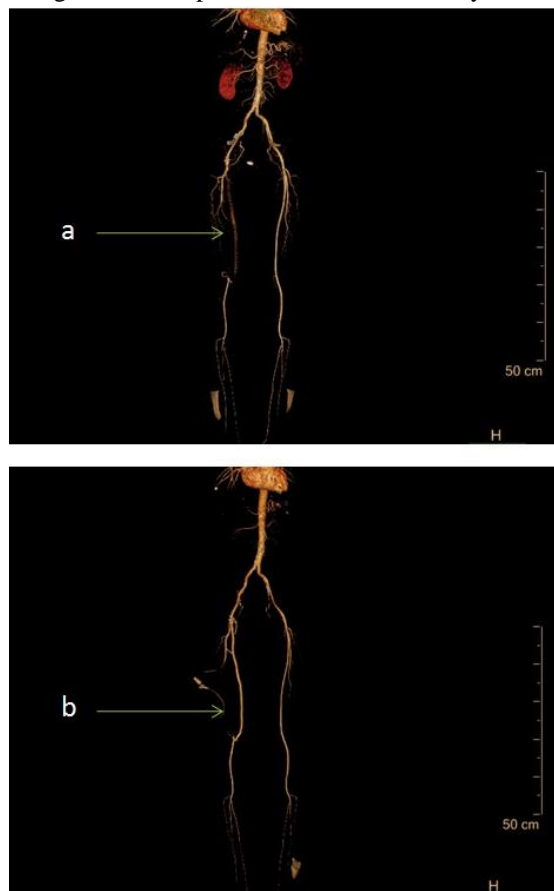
a: before treatment CT angiography of an ALI patient, the arrow shows the graft thrombosis, b: after treatment CT angiography of the same patient, arrow shows the open graft (Combined thrombolytic and surgical adjuvant embolectomy procedures are performed in this patient.)
